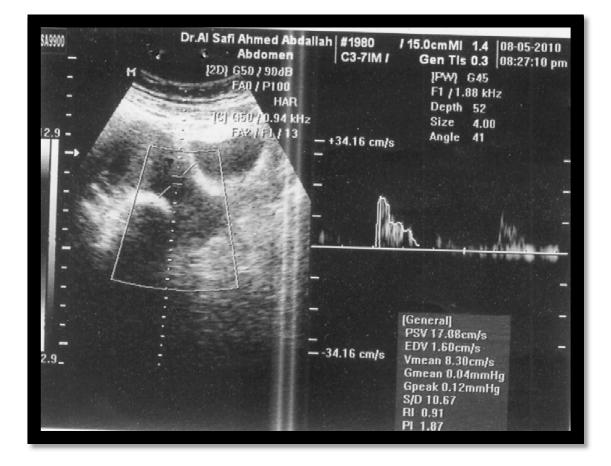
abdominal color Doppler scan showing incomplete abortion for 22 old lady complains from (RPL)
